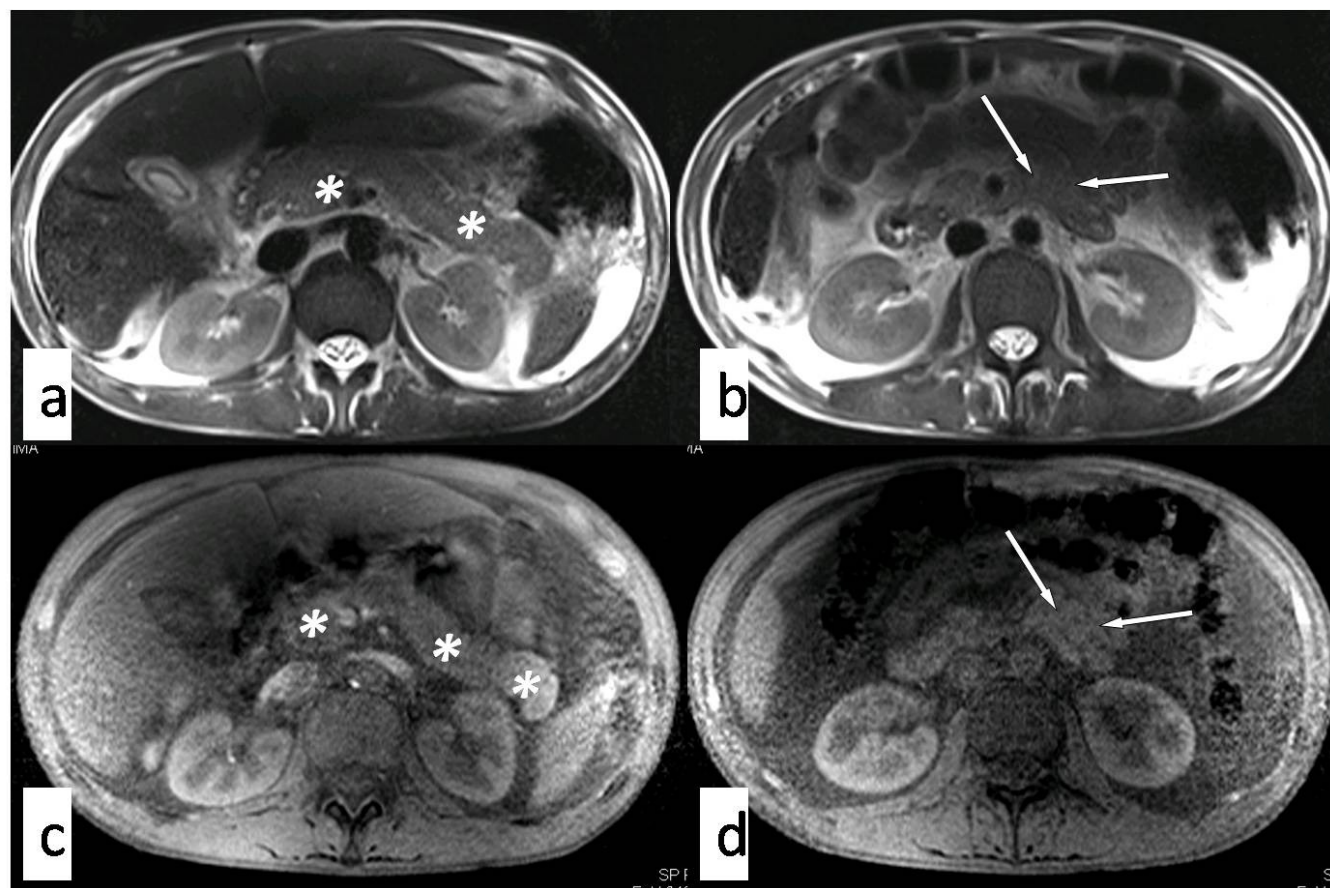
T2-weighted (a and b) and T1-weighted fat-saturated (c and d) axial MR images showing soft tissue lesion in the mesentery (white arrows) having signal character similar to the pancreas (asterix).
